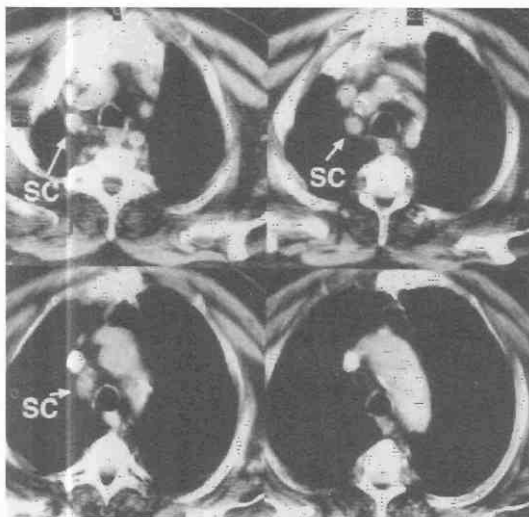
Tortuous great vessels. Contrast-enhanced CT shows tortuous right brachiocephalic and subclavian artery (SC) causing a right paratracheal "mass." Calcifications can be seen within the arterial wall.
